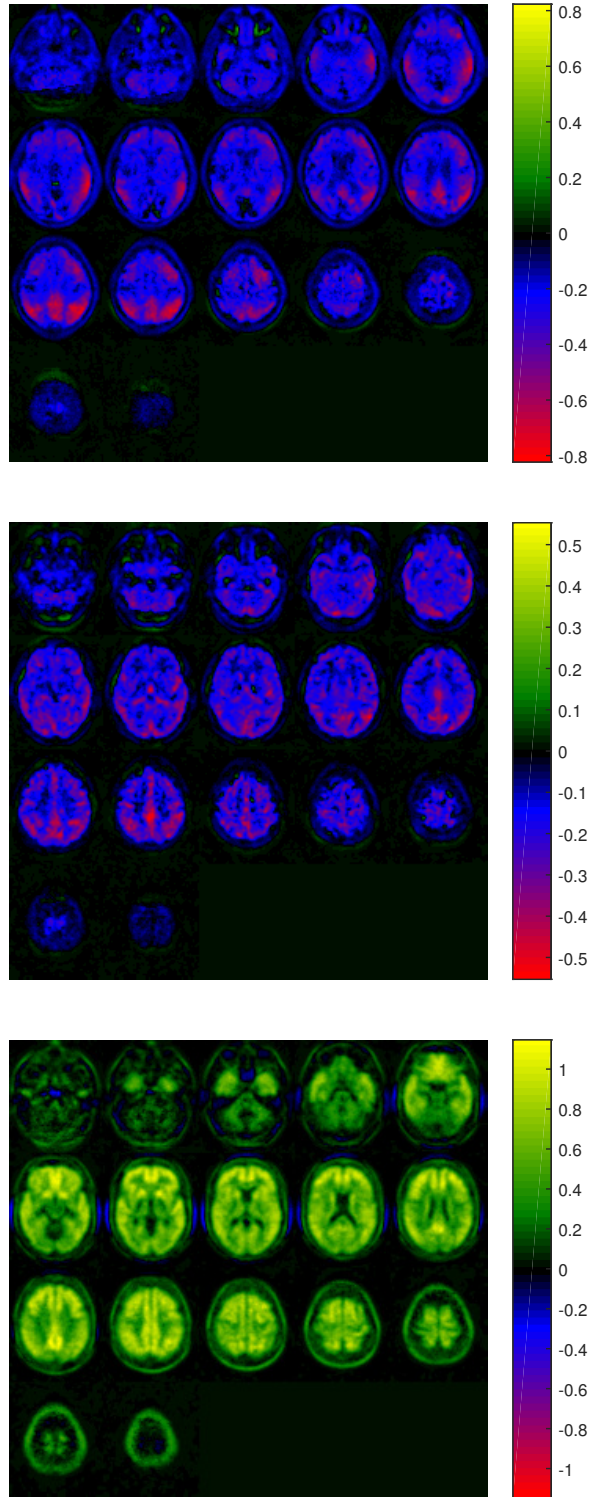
Brain map containing the first column of \mathbf{X} loading (matrix \mathbf{P} in equation 2) corresponding to the PLS decomposition of FDG (top), eFBB (middle) and sFBB (bottom) data and their labels.
